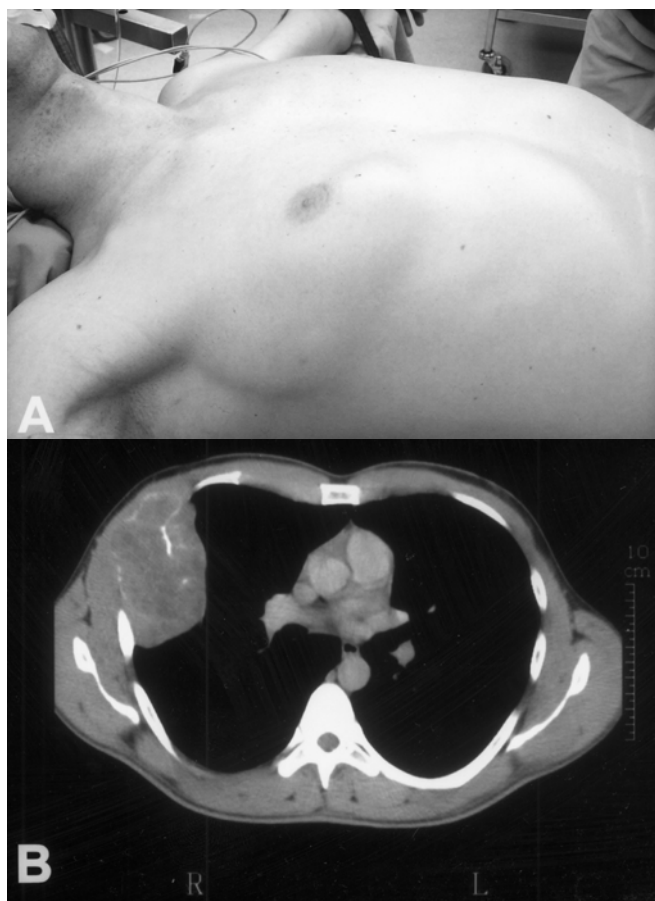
[A] Right chest wall tumor. [B] CT of the chest showing the anterior chest wall mass protruding into the right hemithorax.
